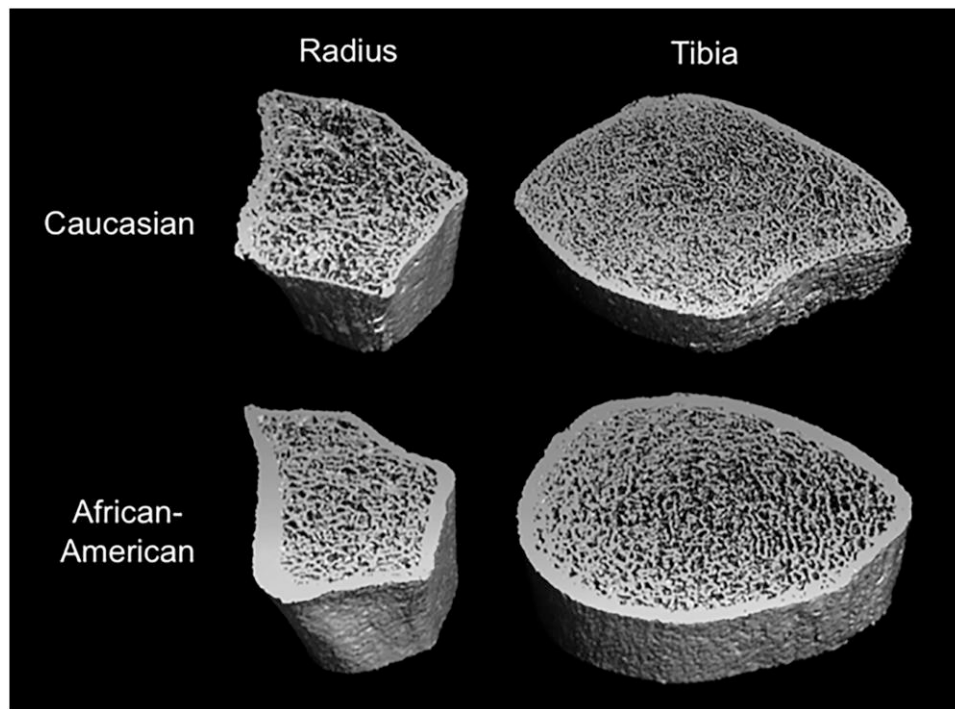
High-resolution peripheral quantitative computed tomography scans of the radius (left) and tibia (right) in a White participant (top) and Black participant (bottom). The thicker cortical and trabecular bone of the Black participant is apparent at both the radius and the tibia. Reproduced with permission from Putman et al (33).
